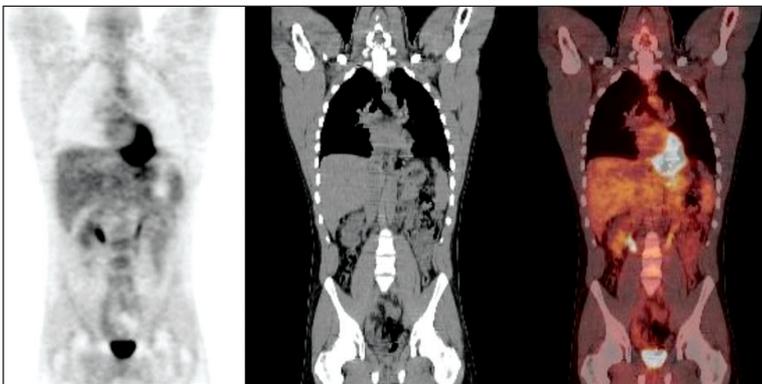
PET, CT and fused PET-CT imaging in a normal patient
